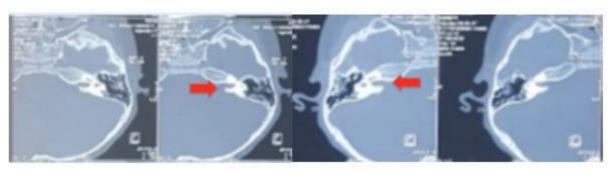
High resolution mastoid CT scan examination
